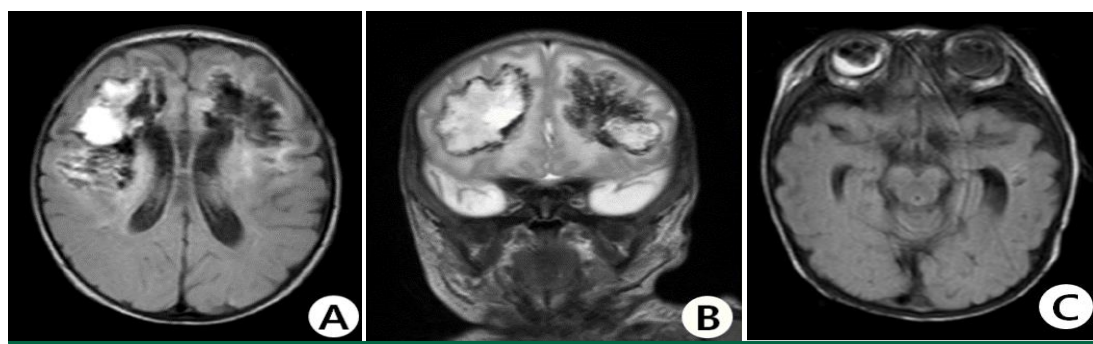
Case 2 infant: Brain magnetic resonance images (T2-weighted images) show bilateral intracerebral hemorrhage before ventriculo peritoneal shunt surgery in the frontal lobe (A, B), and intraventricular, subarachnoid, and vitreous hemorrhages in T2-weighted flair image (C).
